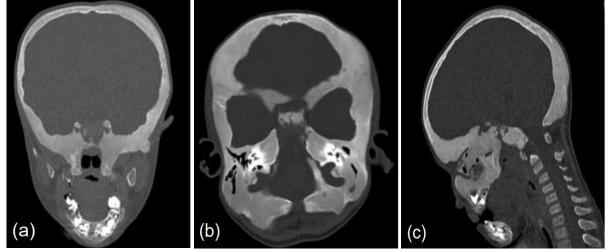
Brain CT-angiography in coronal (a), axial (b) and sagittal (c) sections showing the ground-glass appearance, diploid enlargement and symmetrical hypertrophy of the facial bones, with near-total filling of all facial sinuses, compatible with craniofacial fibrous dysplasia
